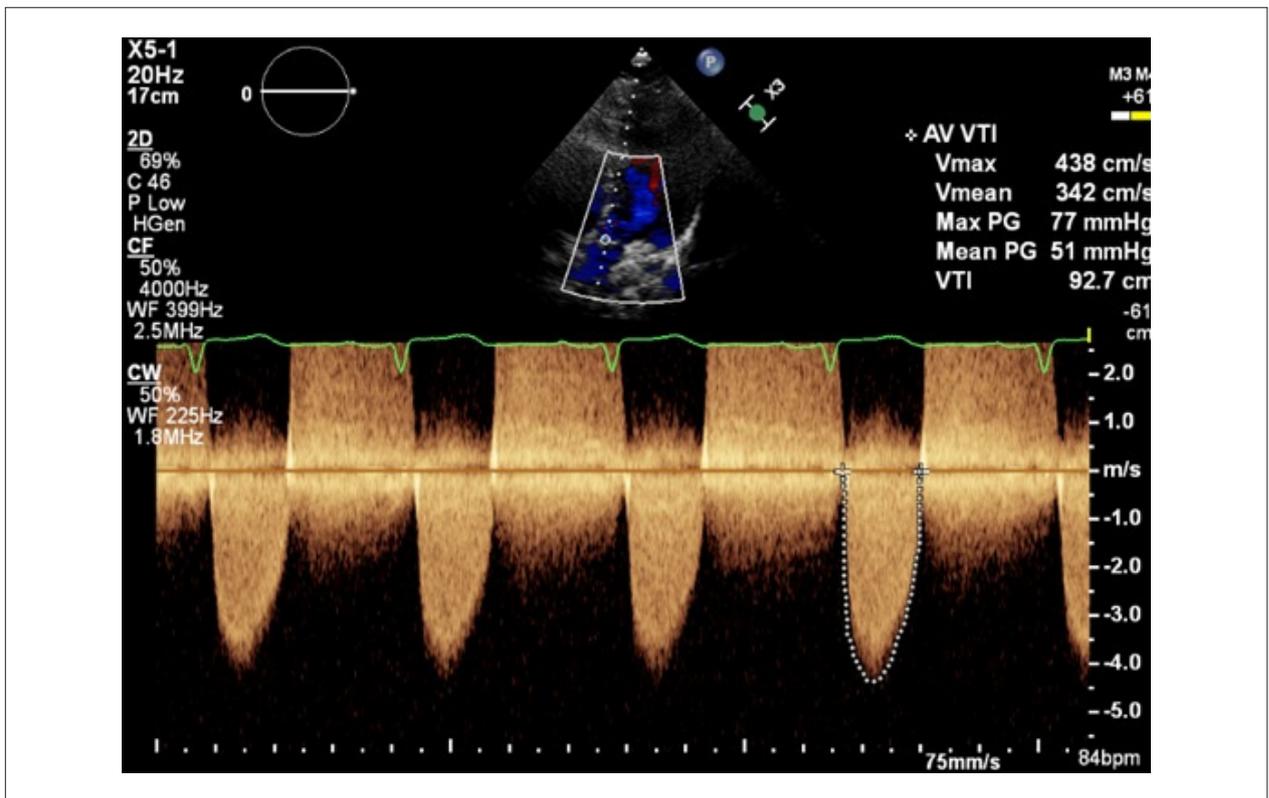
Análise de fluxo transvalvar aórtico, ao Doppler contínuo, evidenciando altas velocidade e gradientes
